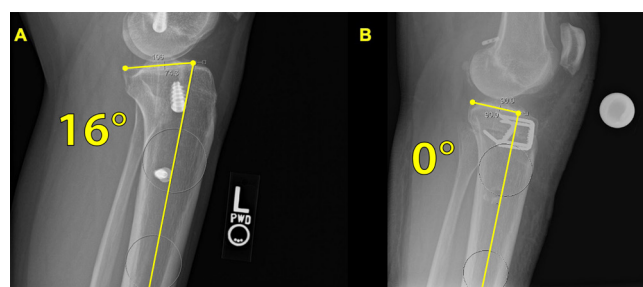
(A) Sagittal view radiograph of a failed primary anterior cruciate ligament reconstruction case. This image demonstrates an increased posterior tibial slope ($\geq 12^\circ$), which was an indication for this patient to undergo an anterior closing wedge tibial osteotomy to correct the posterior tibial slope. (B) Postoperative day 1 radiograph following the anterior closing wedge tibial osteotomy, showing correction of the posterior tibial slope. This procedure was performed as stage one of a two stage revision ACLR.
